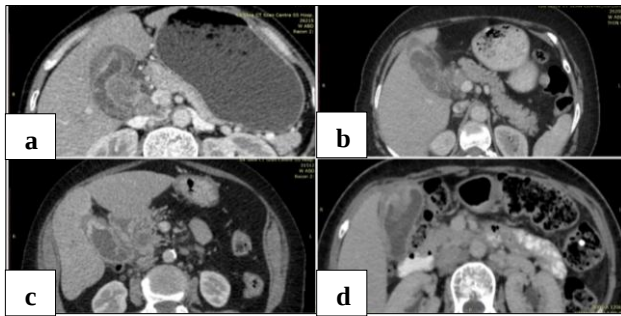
Contrast enhanced CT scan showing type II enhancement pattern in a thickened gall bladder wall [strongly enhancing thick inner layer (>2.6 mm) with a weakly enhancing or non-enhancing thin outer layer (>3.4 mm)], with various accompanying pathologies (a) thickened two layered wall with maintained pericholecystic fascia, (b) inhomogeneous lesion and thickened pericholecystic fascia, (c) inhomogeneous lesion and maintained pericholecystic fascia, and (d) with associated focal mass lesion.
